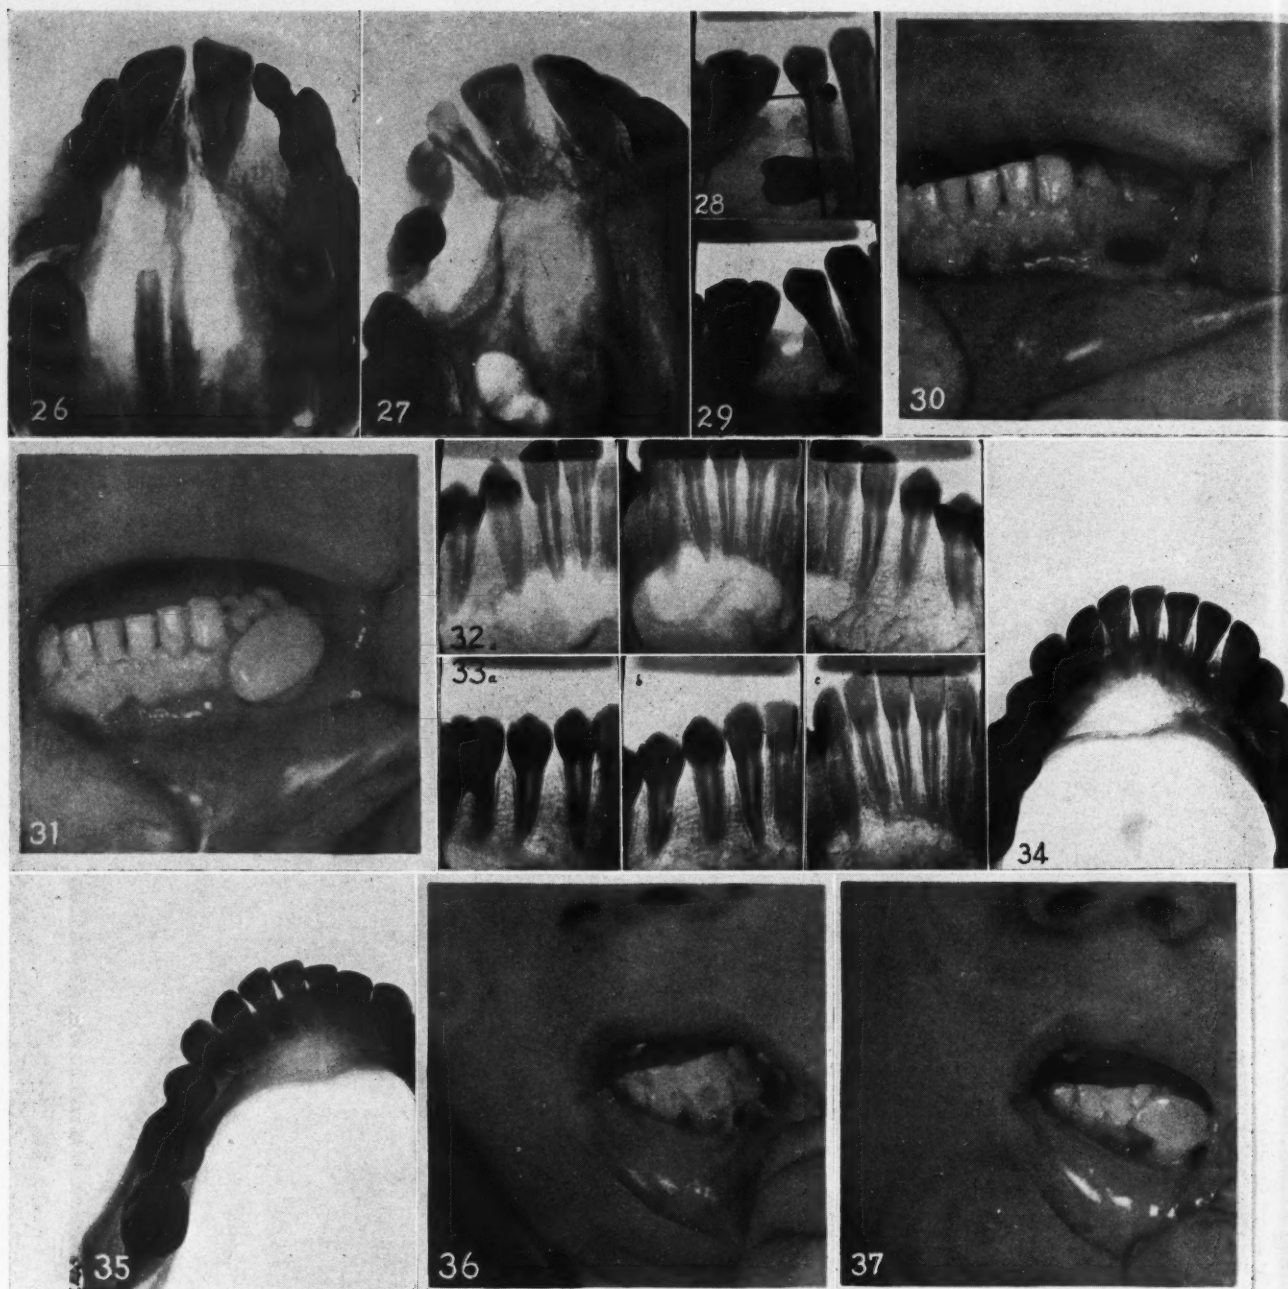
Case 5—Postoperative roentgenogram taken May 9, 1932.
